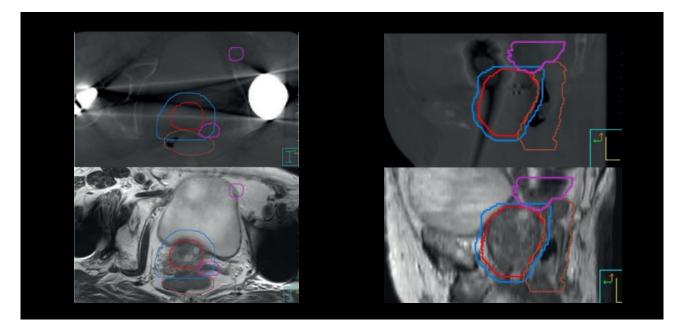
CBCT (top) and MR-Linac (bottom) images of a patient with bilateral hip implants. On the CBCT streaking artefacts are observed obscuring the target area. Images courtesy of The Royal Marsden Hospital.
